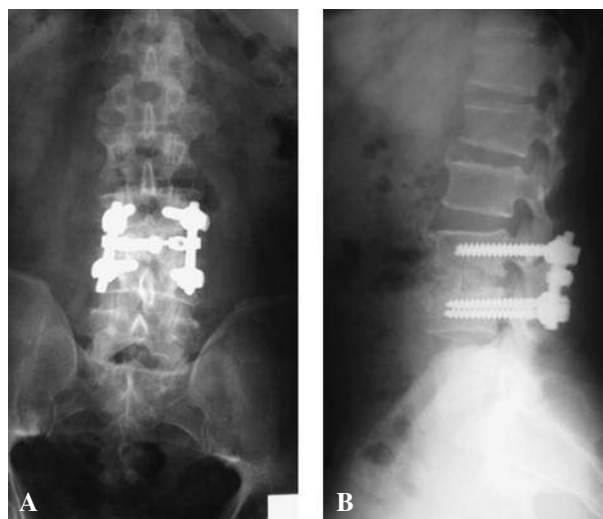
A, B. Postoperative antero-posterior and lateral radiographs showing L3-L4 anterior reconstruction and posterior spinal instrumentation.
